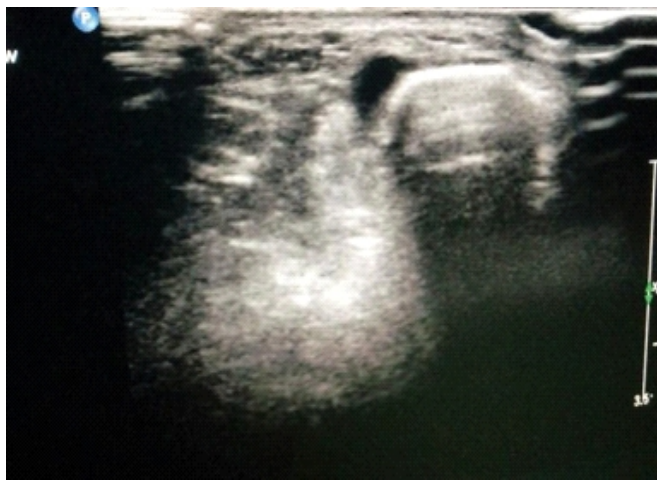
Ultrasonography of the lesion showing a hypointense oval shadow in the subcutaneous plane.
